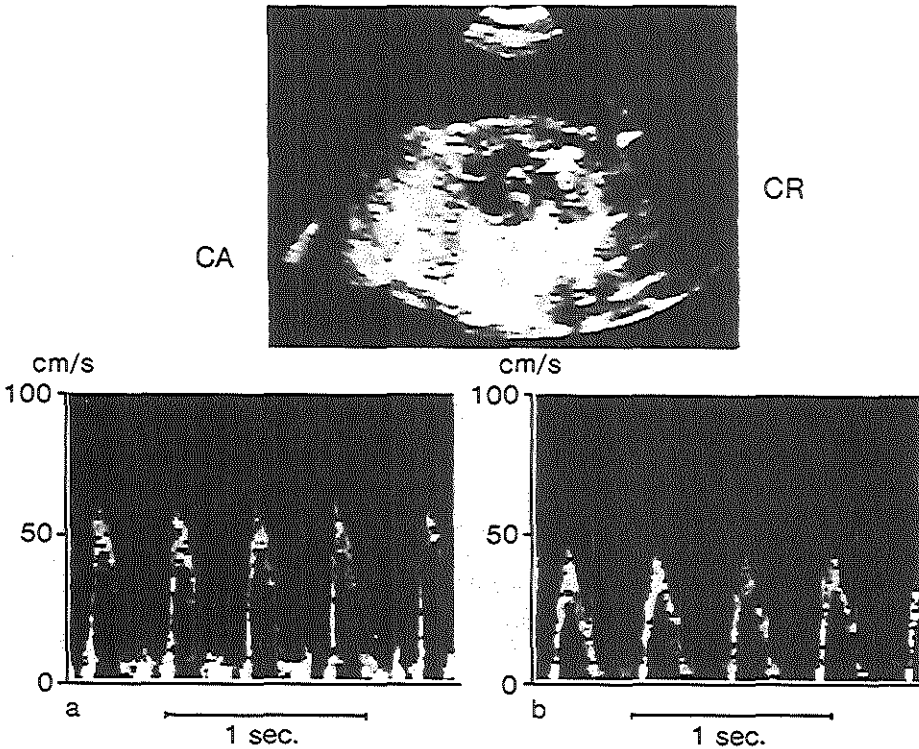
Two-dimensional short axis/pulmonary arterial view of the human fetal heart with Doppler flow velocity waveforms from the pulmonary artery (arrow) during normal pregnancy (a) and IUGR (b). CR, cranial; CA, caudal.
